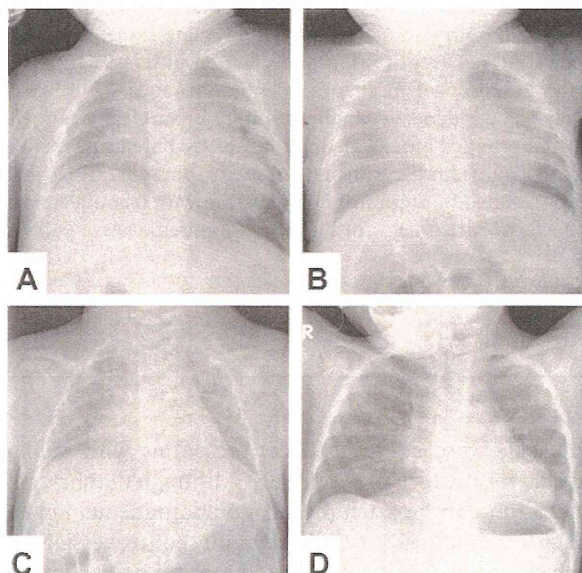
A chest roentgenogram of patient 1 prior to surgical plication revealed an elevation of the right diaphragm up to the 7th intercostals, and no malformation of costal arches (A). After diaphragmatic plication, the right diaphragm shifted downward at 2 months (B). A chest roentgenogram of patient 2 prior to surgical plication revealed bilateral elevation of the diaphragm up to the 7th intercostals, and no malformation of costal arches (C). After diaphragmatic plication, bilateral diaphragms were shifted downward at 15 months (D).
